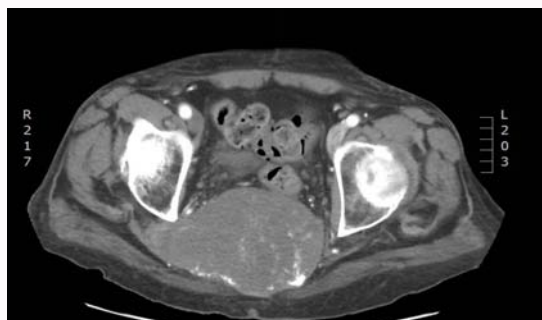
Computed tomography axial view of sacral chordoma.
